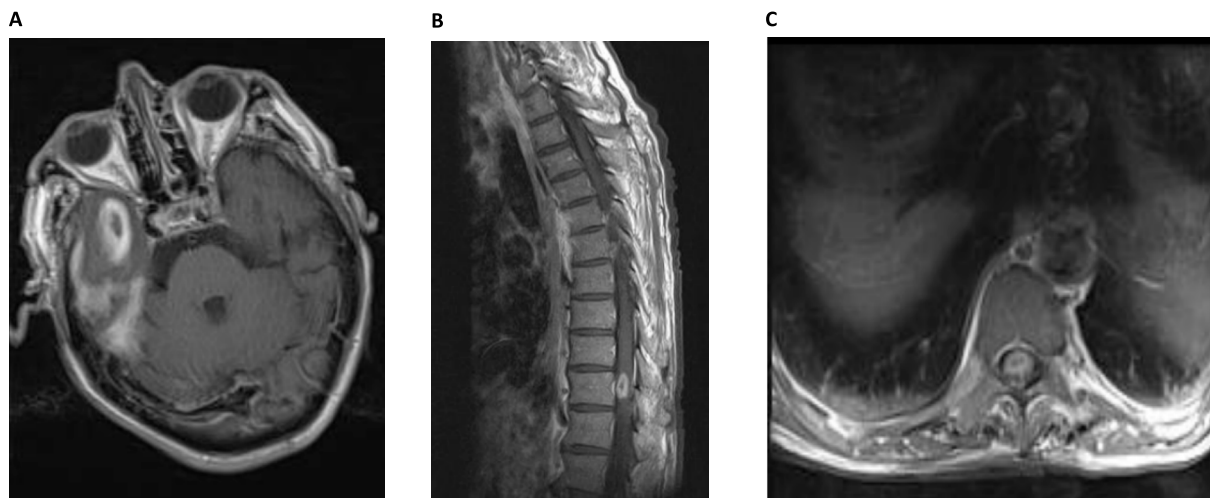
Different sequences of magnetic resonance imaging (MRI) finding in chronic lymphocytic leukemia (CLL) patient, A. T1 with GAD axial view of brain MRI, C. T1 with GAD sagittal dorsal view of spine with open ring sign in T9-T10, D. T1 with GAD axial view of spine with open ring sign in T9-T10
